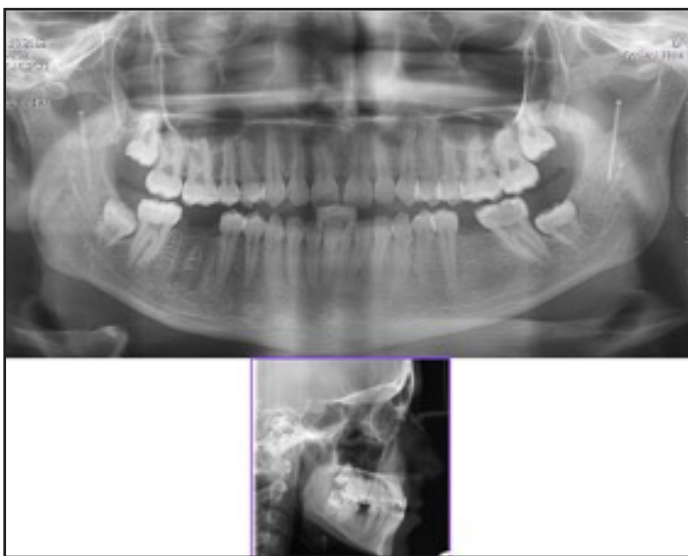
Panoramic radiograph and cephalometric radiograph of case 2
